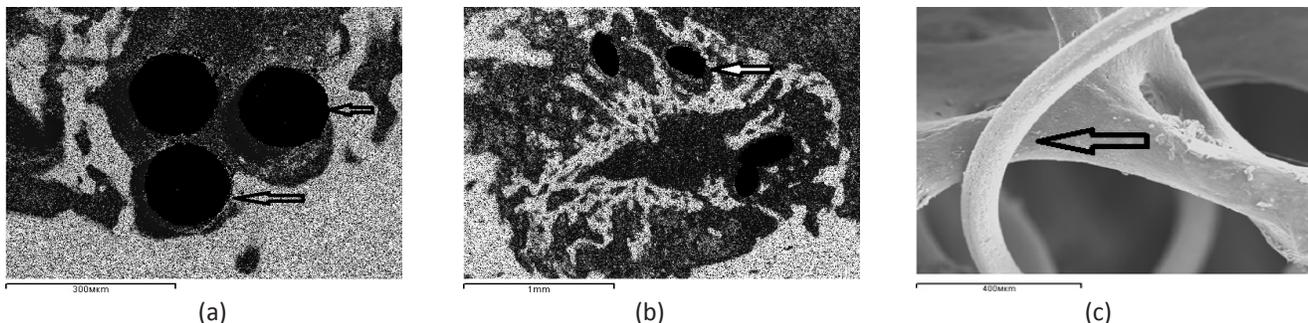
Reparative osteogenesis in the metaphyseal defect 7 (a) and 14 (b, c) days after surgery, arrows indicate the areas of osteointegration; a, b – maps of x-ray electron probe microanalysis, image in characteristic X-ray emission of calcium atoms, c – SEM (organic components removed with 6% sodium hypochlorite solution), magnification: a - $\times 100$, b - $\times 25$, c - $\times 70$.
